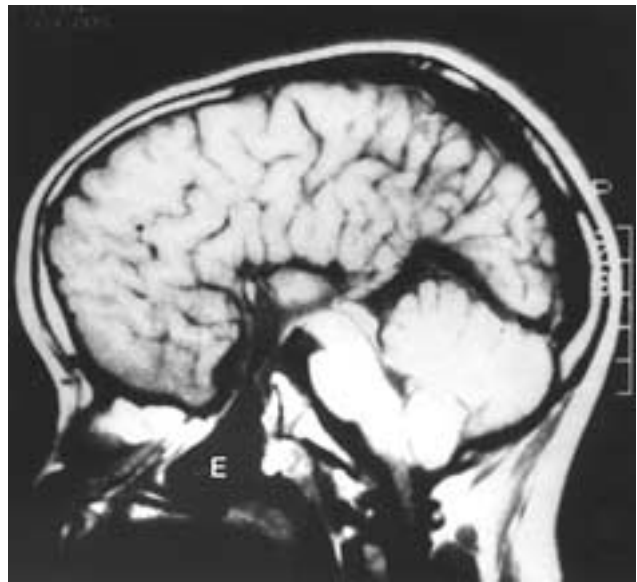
Spenoethmoidal encephalocele. Sagittal T1-weighted MR image shows the encephalocele (*E*) extending into the nasal cavity, resting on the hard palate. The connection can be followed through the anterior sella and anterior sphenoid. This would be the approximate position of the fusion line of pre- and postsphenoids. The cystic abnormality did contain brain tissue along the wall and therefore qualifies as an encephalocele.
